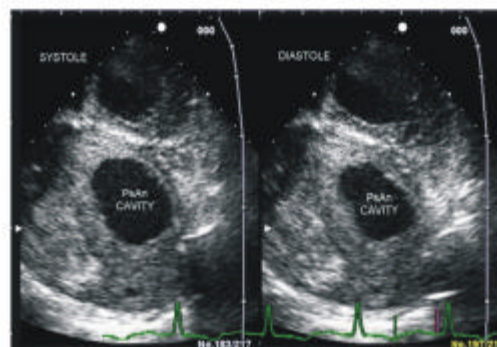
Modified parasternal short axis views of the pseudoaneurysm cavity. It expands in systole and collapses in diastole
